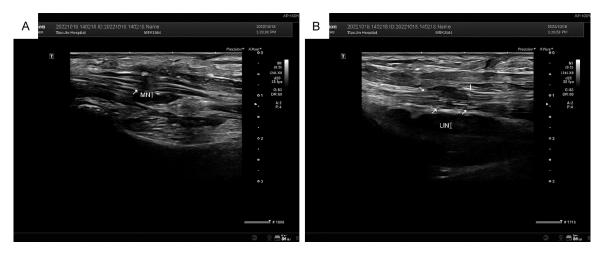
Representative ultrasound images of median and ulnar nerves. A: Ultrasound image of the median nerve; B: Ultrasound image of the ulnar nerve.
